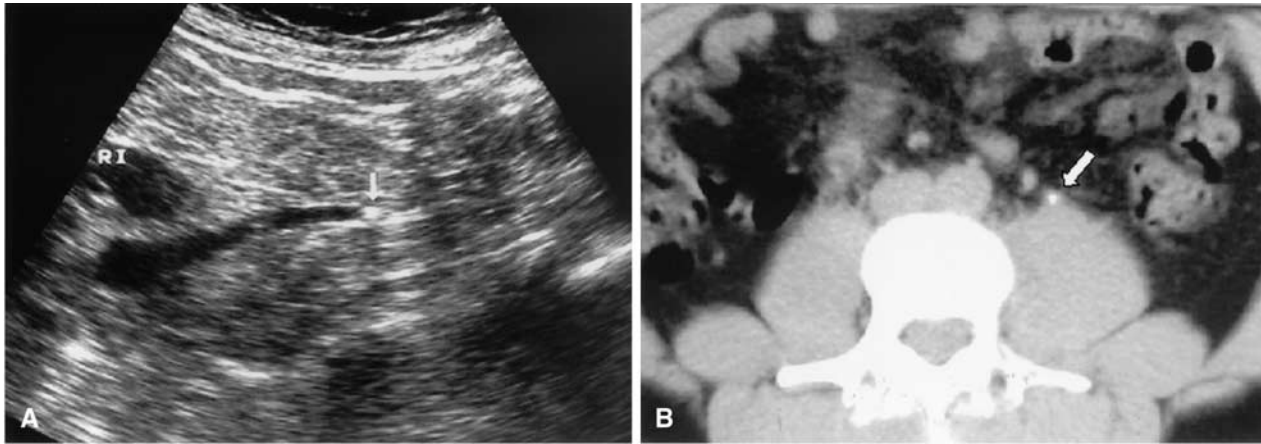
Acute left flank pain in a 60-year-old woman. A Longitudinal US scan with patient in the left lateral decubitus position shows a stone (*arrow*) in the middle ureter that produces slight ureteral dilatation and hydronephrosis. B CT demonstrates a left mid-ureteral calculus (*arrow*) surrounded by soft tissue (rim sign).
